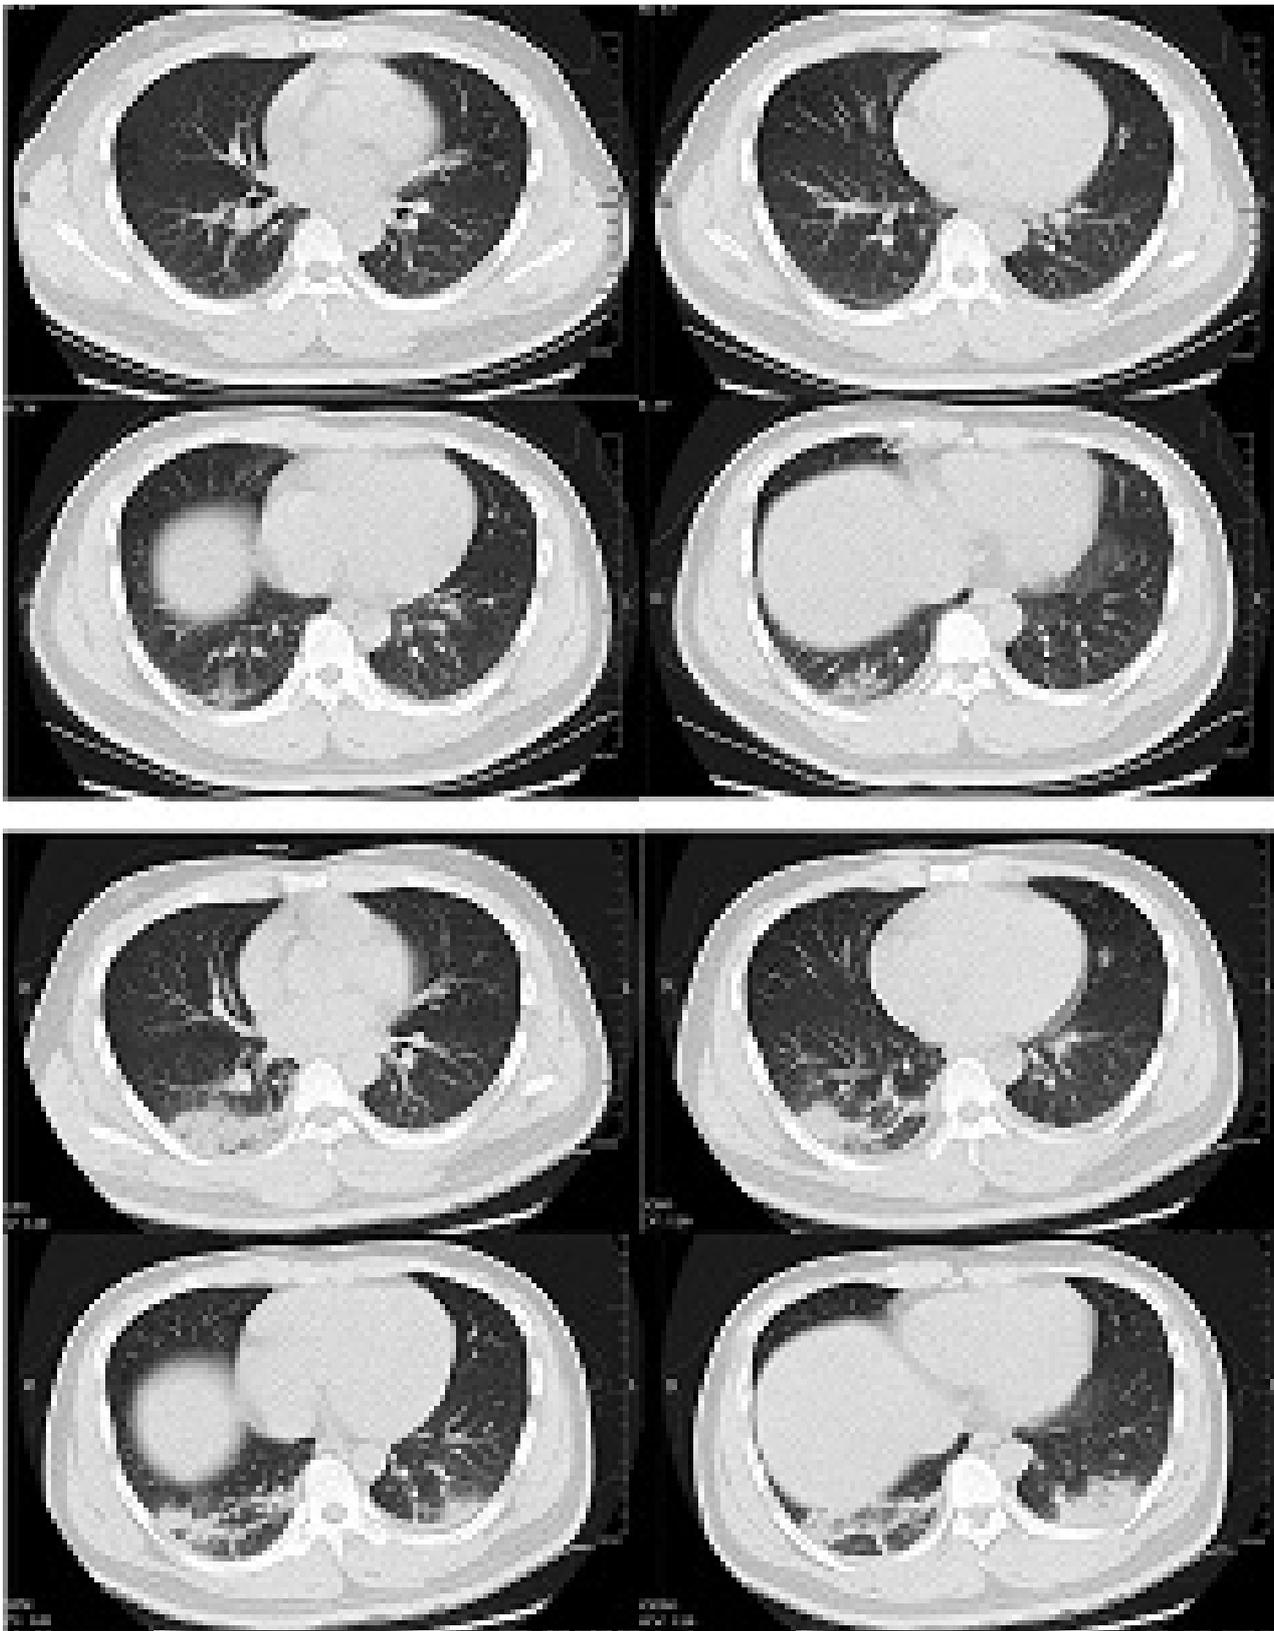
Transverse CT scans from a 32-year-old man, showing ground-glass opacity and consolidation of lower lobe of right lung near the pleura on day 1 after symptom onset (top panel), and bilateral ground-glass opacity and consolidation on day 7 after symptom onset
